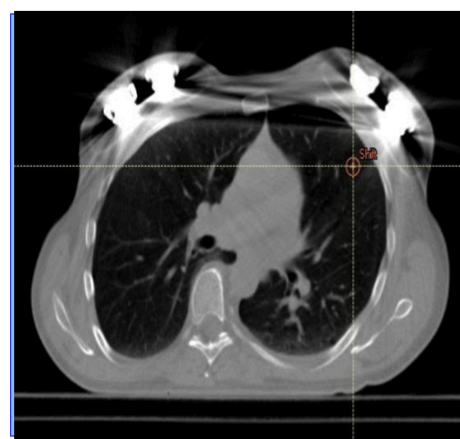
CT Axial view of a patient with bilateral AlloX2
